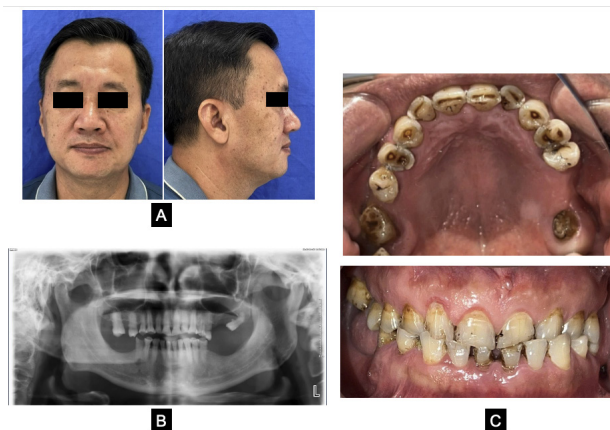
Case 2. Before treatment (male patient), frontal and lateral views of the face (A), panoramic radiograph (B), and intraoral frontal and right lateral view (C).
